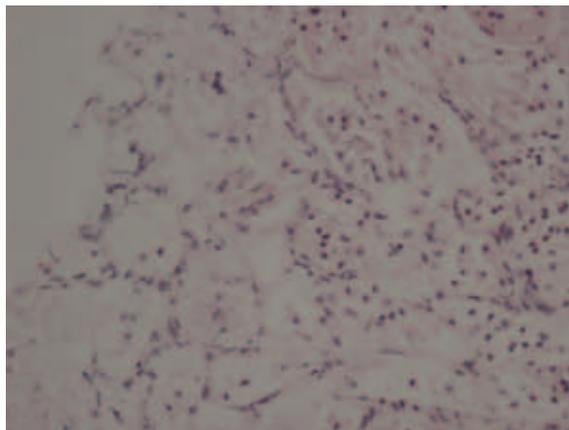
Disruption of kidney tissue caused by high focused ultrasound. B) Sonication time 240 sec
